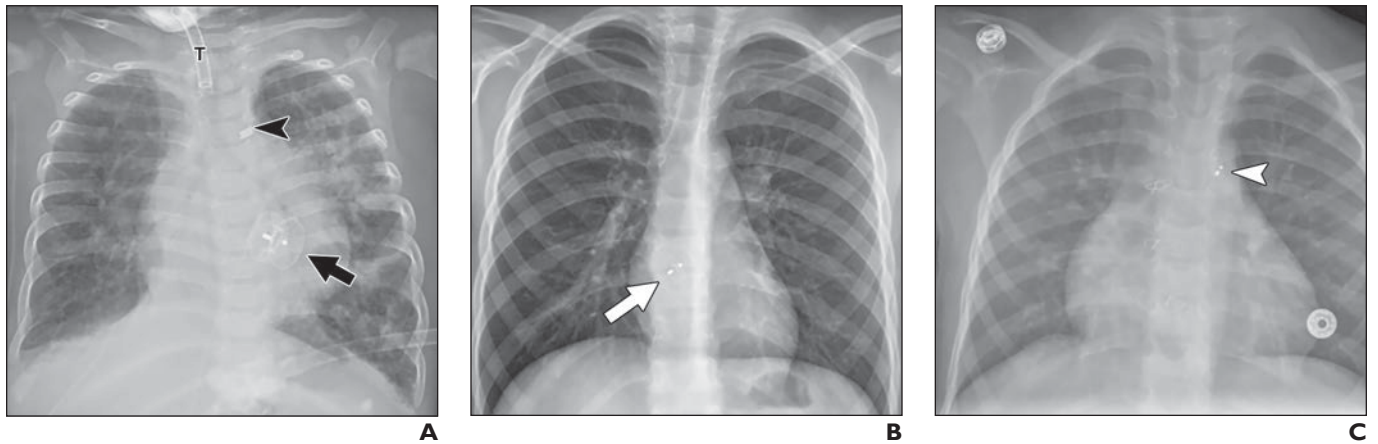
Radiographic appearance of cardiac closure devices.
